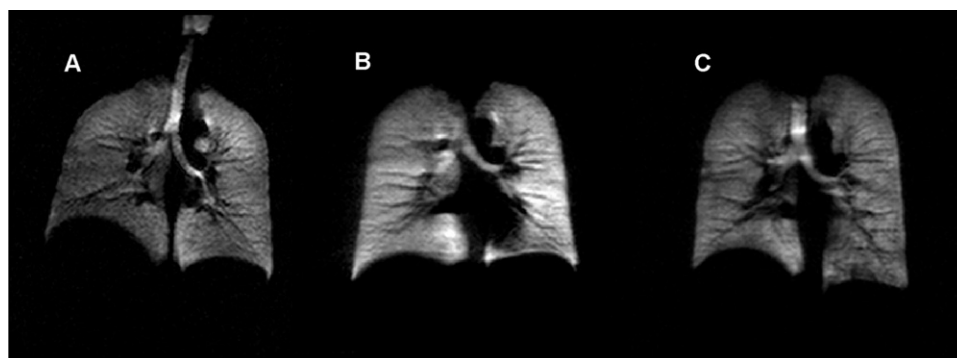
Middle-aged healthy volunteers ^3He magnetic resonance imaging. (a) Subject 6-1001 45-year-old female. (b) Subject 6-1003 42-year-old male. (c) Subject 6-1010 39-year-old male.
